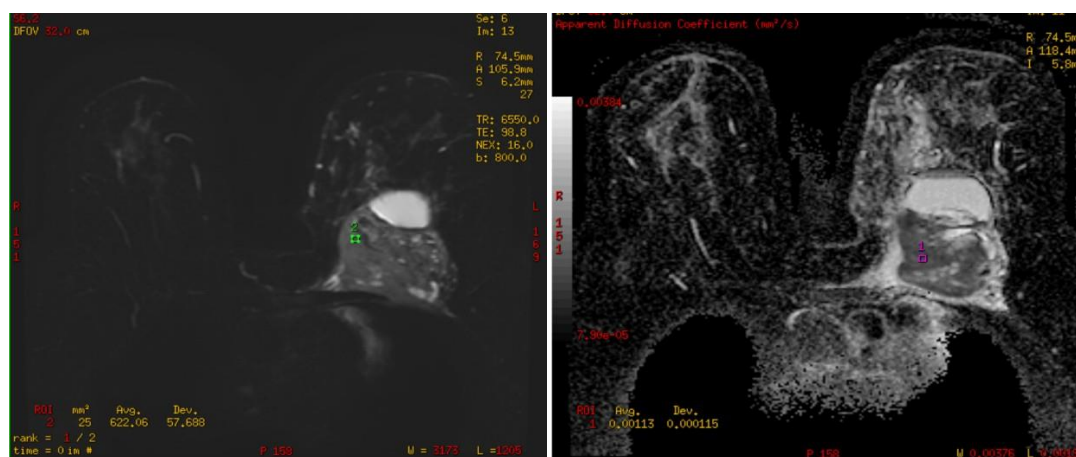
DWI and ADC map showing breast mass lesion with ROI placement giving ADC value of $1.13 \times 10^{-3} \text{ mm}^2/\text{sec}$.
